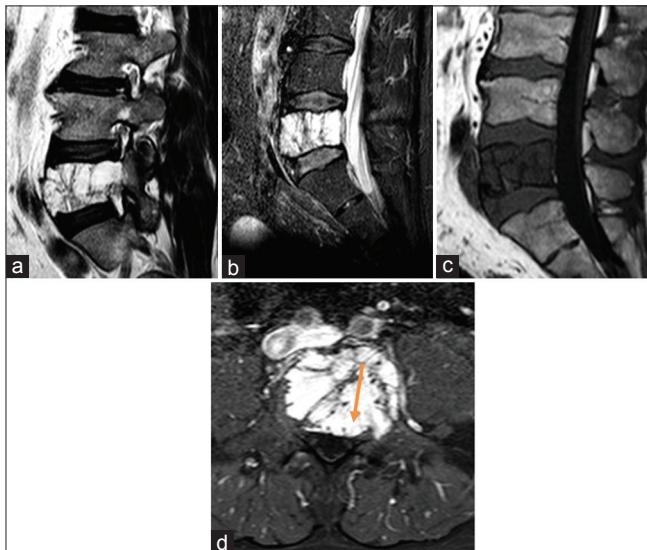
Lumbar magnetic resonance imaging images show a lesion of L5 with hyperintensity in T2 and short-tau inversion recovery-weighted images (a and b), and hypointensity on T1-weighted image (c). Axial short-tau inversion recovery-weighted image (d) show spinal canal invasion and compression of the left L5 root (arrow)
